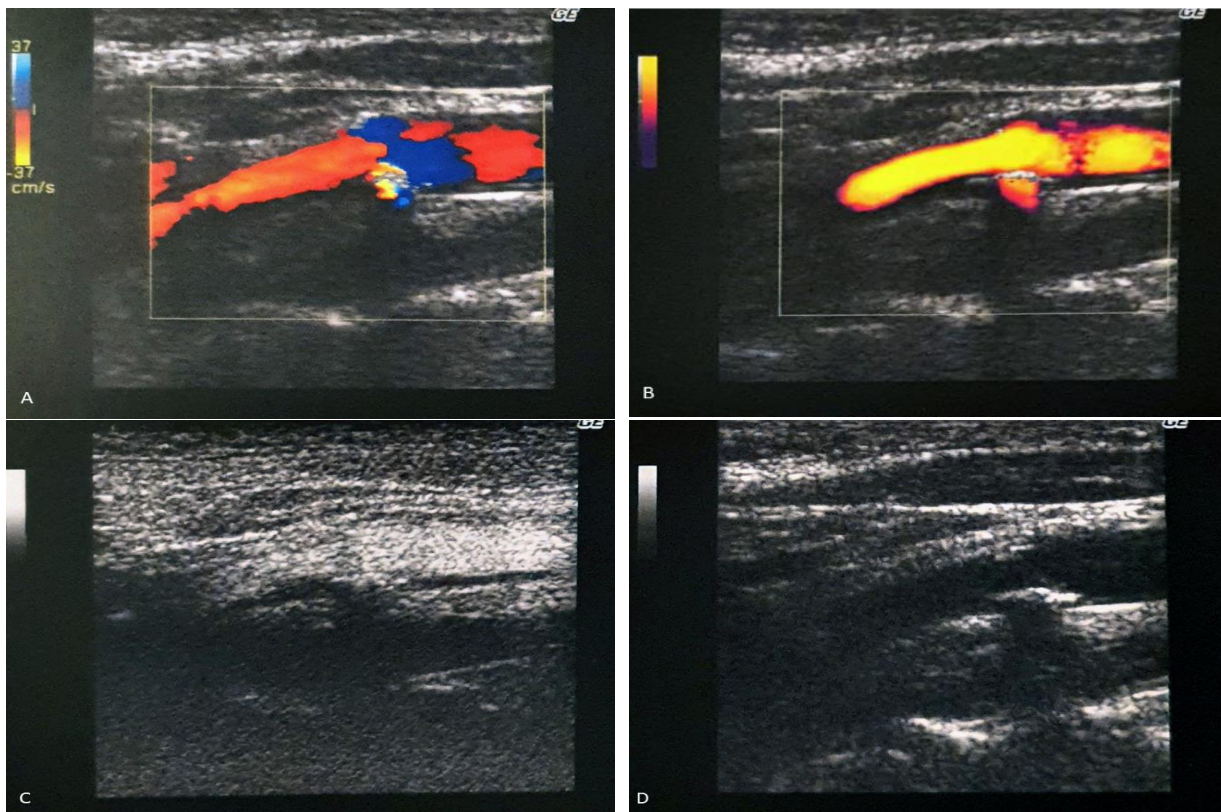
74-year-old male patient color with a calcified plaque in the carotid artery. Color (A) and power Doppler (B) suffer from “twinkling artifact” seen posterior to the calcified atheroma plaque. B-flow (C) demonstrates the plaque and flow without artifacts. Characteristics of plaque in B-mod (D).
